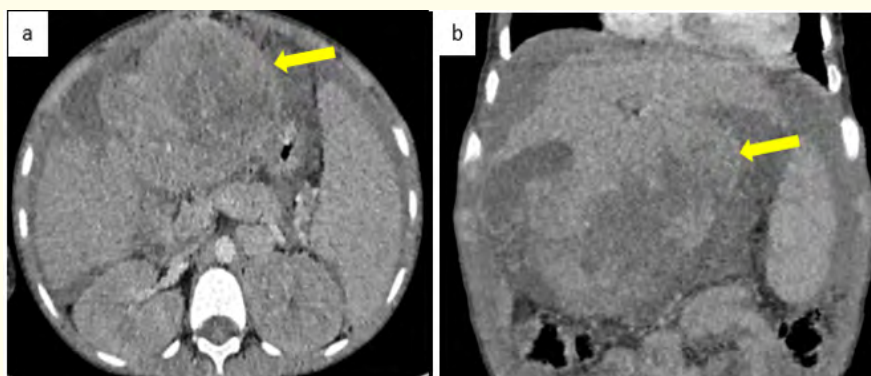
Contrast-enhanced abdominal-pelvic CT scan. Axial plan (a) and coronal reconstruction (b). Intraperitoneal mass in the supramesocolic region, appearing to originate from the liver (smoothly connected to hepatic segments IV and III with a claw sign). The mass is relatively well-defined, multilobulated, and has soft tissue density with heterogeneous enhancement after contrast injection, containing central necrotic areas (yellow arrow). Associated findings include a dysmorphic liver with irregular contours, splenomegaly with portosystemic shunting, and mild intraperitoneal effusion.
